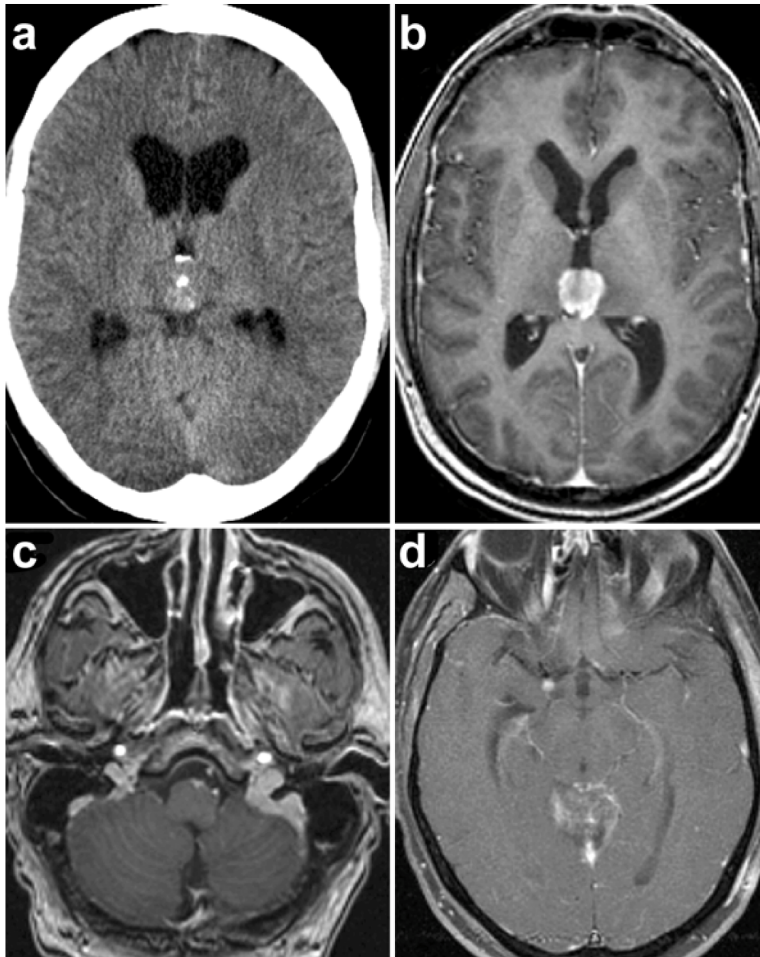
Noncontrast computed tomography scan of the head showing calcified pineal region mass (a). Axial contrast-enhanced T1-weighted magnetic resonance imaging of the brain with contrast showing heterogeneously enhancing mass with central necrosis (b) and enhancing leptomeningeal disease anterior to the medulla and within the cerebellar folia (c). (d) Enhancing mass along the medial aspect of right temporal lobe representing an additional metastatic focus.
